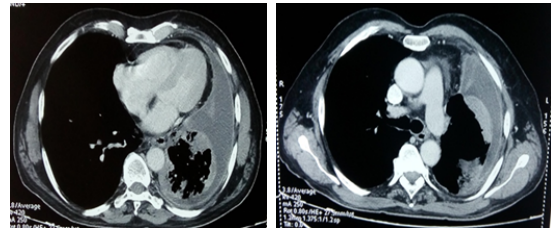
Axial CT images demonstrate a left side pleural effusion with collapsed lung and area of consolidation.
